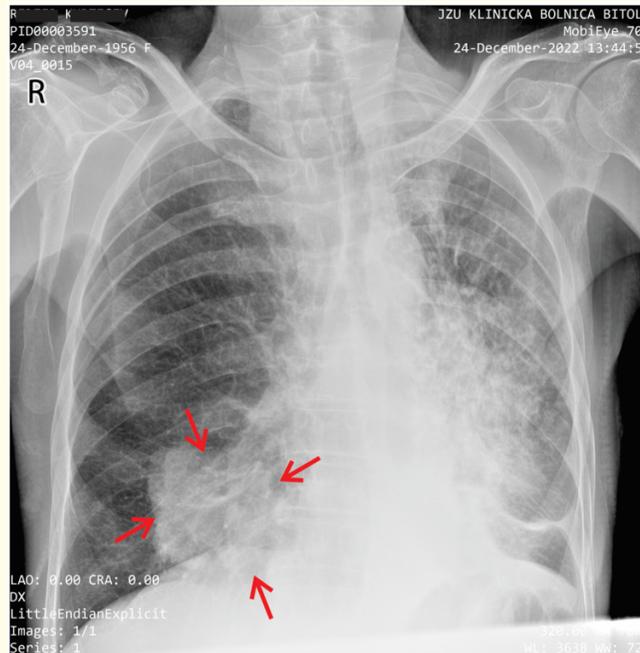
Chest X-ray showing bilateral bronchopneumonia (consolidation in the central and inferior part of the left lung and in the inferior part of the right lung, the marked region was misinterpreted).
